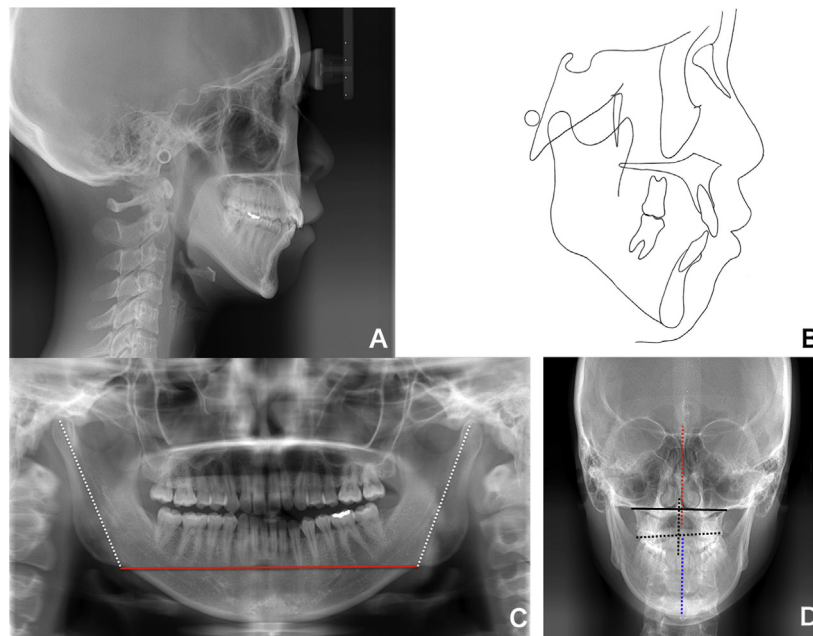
Patient 2: A-D, pretreatment cephalometric radiograph, cephalometric tracing, panoramic and PA radiographs. A substantial difference in the length of the condyle is observed (*white* in C). The cant of the occlusal plane (*black* in D) and the midline deviation of the mandible (*blue* in D) are also observed in the PA radiograph.
